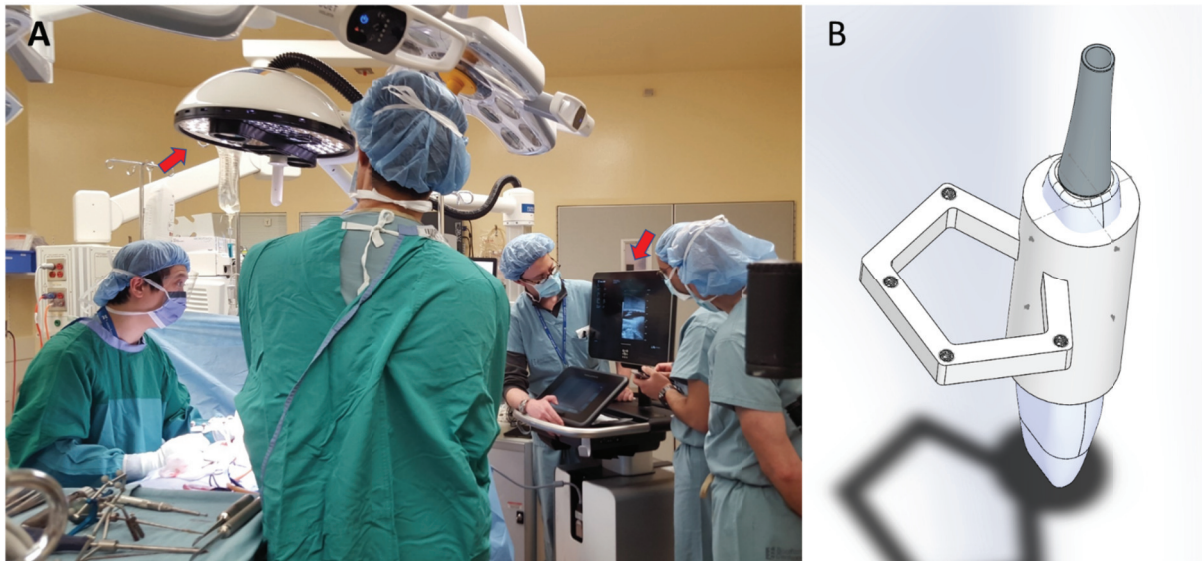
A) Intra-operative navigated ultrasound: Optical topographical imaging system and high frequency ultrasound system are present in the operating theater (red arrows). B) Computer-aided design (CAD) of a tracked high frequency ultrasound probe.
